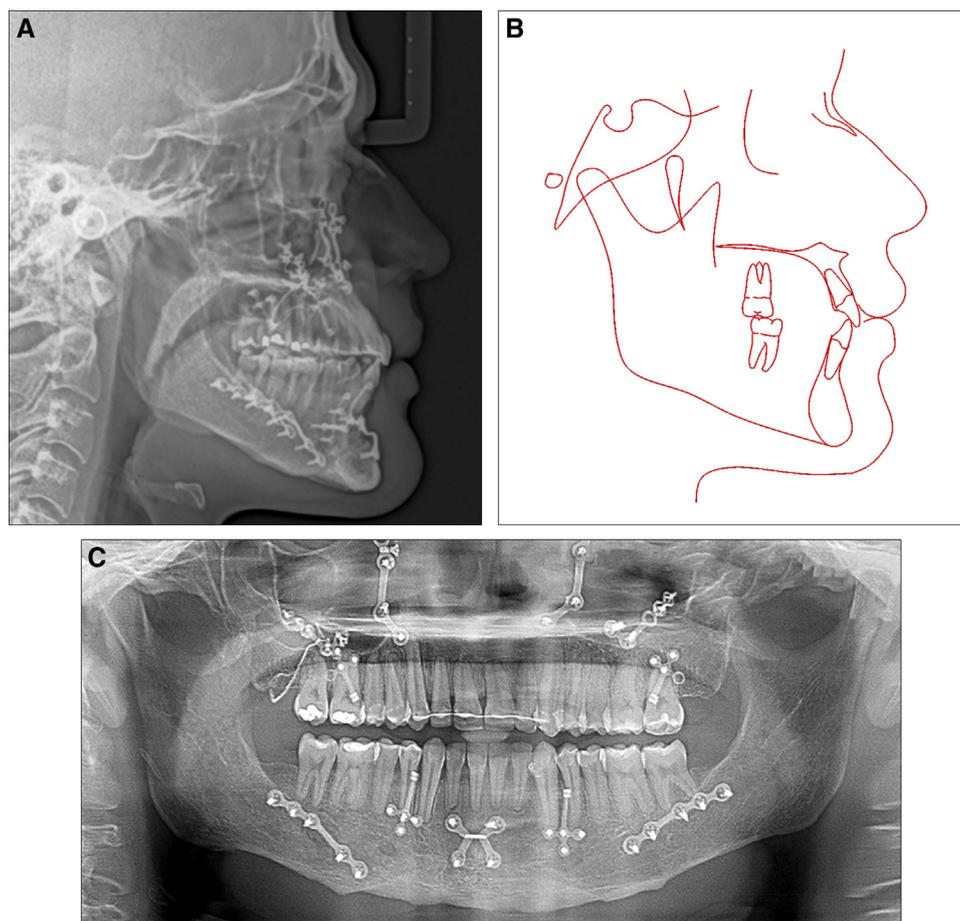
Posttreatment radiographs: A, cephalometric radiograph; B, cephalometric tracing; C, panoramic radiograph.
